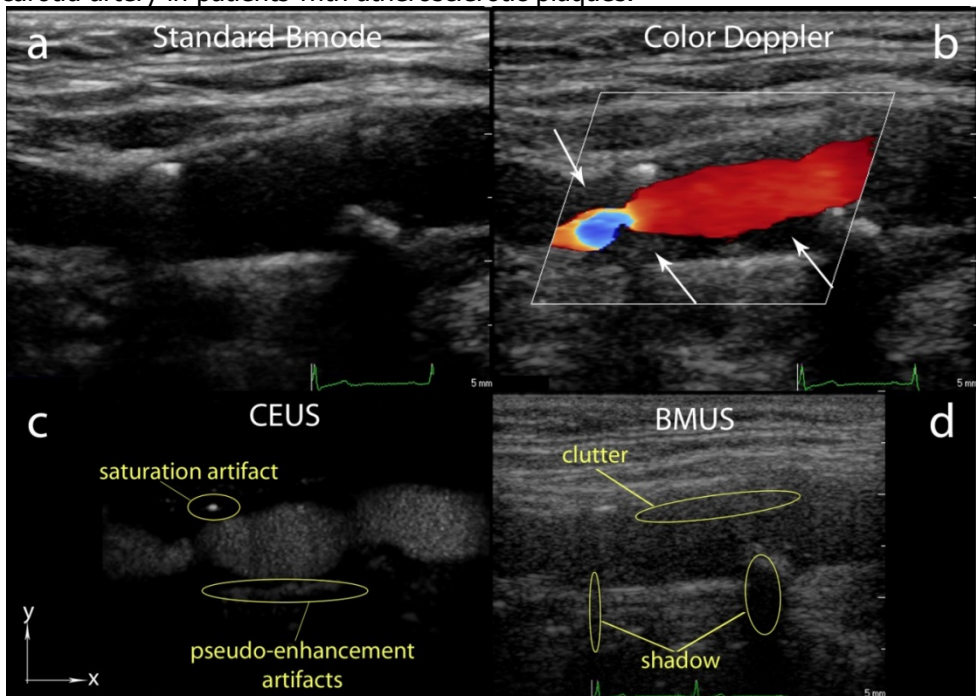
An example of a carotid artery image acquired with different ultrasound techniques. Standard BMUS (a), Color Doppler (arrows show echolucent plaques, blue color shows direction change in the flow) (b), Side-by-side CEUS and B-mode images (c-d). CEUS artifacts are indicated (c). Shadow and clutter in BMUS are indicated (d).
